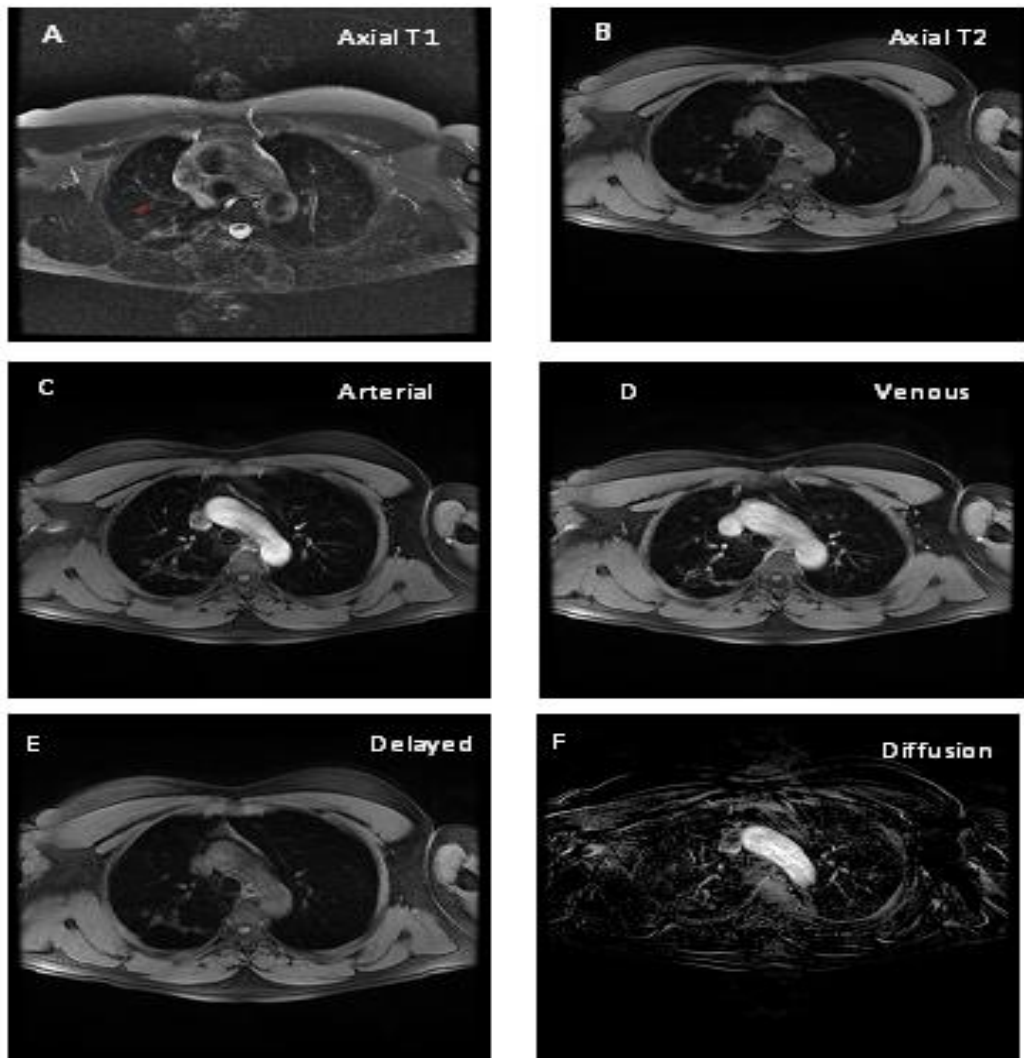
Case number 3. Few bilateral pulmonary nodules the largest seen at right upper lung lobe measures about (1.8x1.6 cm), the nodules showing isointense signal at T1 (A)&T2 (B). While after dynamic post contrast phases that lasts for 4 minutes the nodules showing faint arterial enhancement (C) with persistent enhancement at subsequent phases (no washout)(D&E). ADC value is 2×10^{-3} mm²/s with no evidence of restricted diffusion (F). The time-enhancement curve is of type C (G). CT examination revealed few bilateral calcified pulmonary nodules largest seen at right upper lung lobe measures about 2x1.8 cm representing old granulomatous infection
